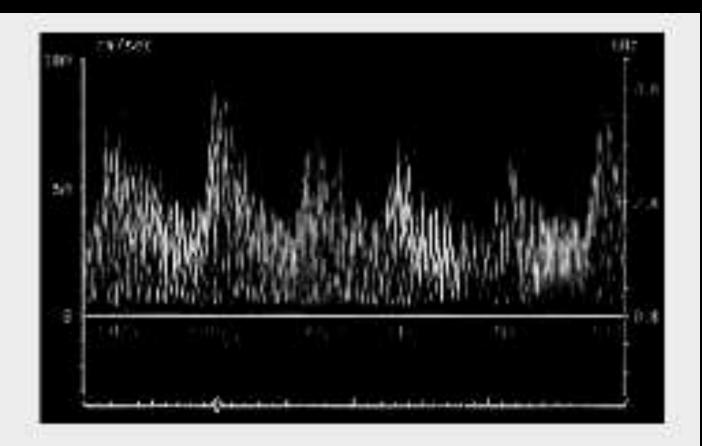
Doppler waveform demonstrating turbulent flow.
